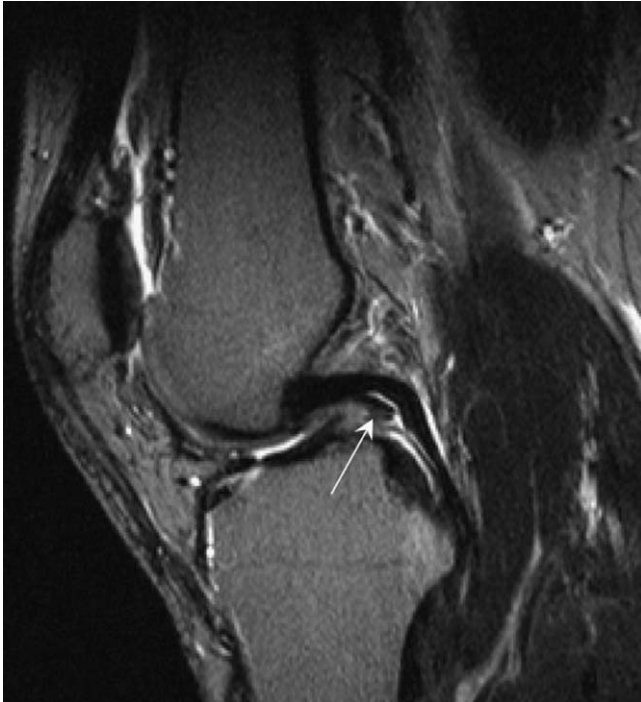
T2-weighted sagittal MRI demonstrating a partial tear of the PCL. Note the elongated posture of the ligament, the posterior position of the tibia relative to the femur, and the high signal intensity present in the ligament midsubstance (arrow). Normal low signal intensity is present in the remainder of intact PCL fibers.
